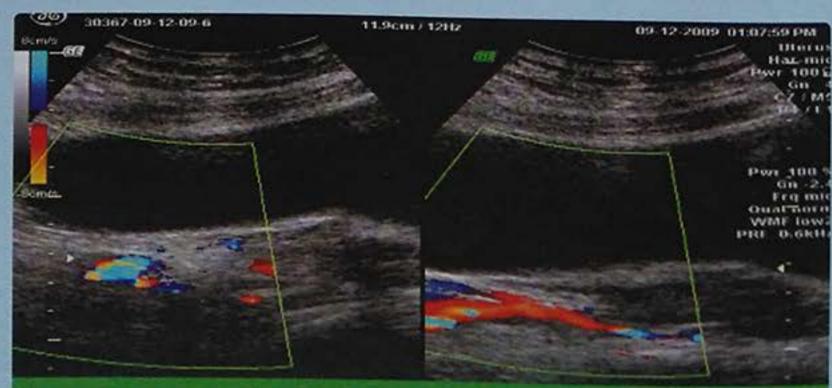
Longitudinal colour Doppler ultrasonography image shows that the cystic structure is filled with blood and has varying colours
